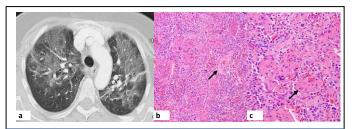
(a) axial computed tomography with diffuse ground glass opacities, (b,c) classic finding of AFOP: intraalveolar fibrin in the form of "fibrin balls" without formation of hyaline membranes (arrows).
